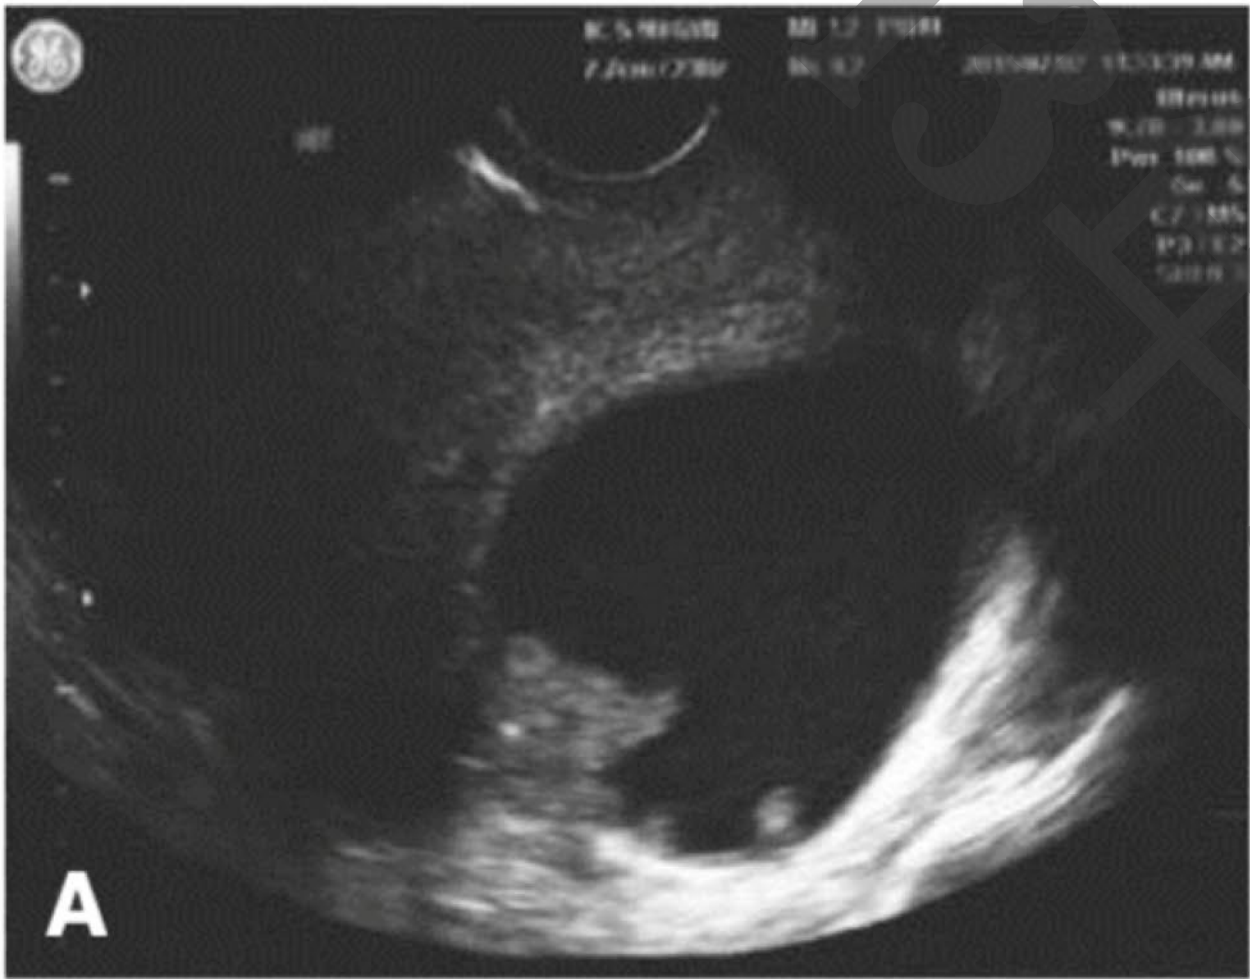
Ultrasound images of the ovaries. A Enlarged bilateral ovaries (left, 6.9×4.7 cm; right, 7.8×5.2 cm) with multiple anechoic areas were detected at five weeks of gestation. B At the 15 weeks of gestational age, the right ovary became solid, and multiple cysts involved the left ovary. At 24 weeks of gestational age, there was right (C) and left (D) ovarian enlargement, with hypoechoic area in the parenchyma and visible rich blood flow signals in the right ovary
